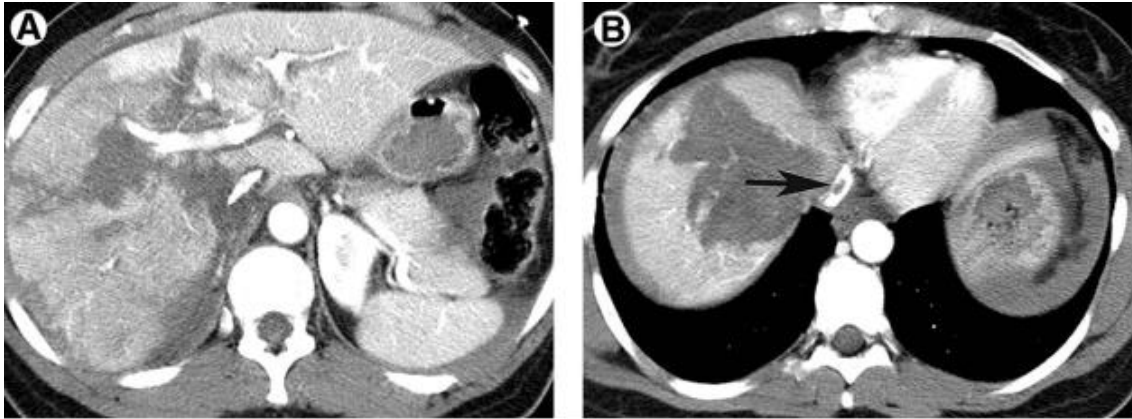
A 42-year-old female sustained a grade IV liver laceration in a fall from a building. (A) Contrast-enhanced axial CT scan through the liver at the level of the portal vein shows deep lacerations involving the dome of the liver and extending to the portal veins and IVC. (B) Contrast-enhanced axial CT scan shows a small thrombus in IVC (arrow) and perihepatic hematoma. No evidence of active vascular extravasation
